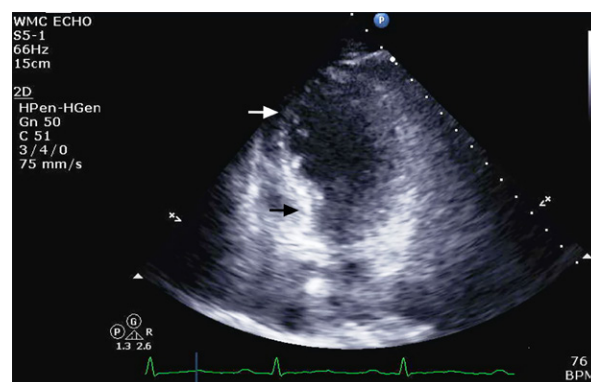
Two-dimensional bedside echocardiogram (4-chamber apical view) shows balloon-like configuration of severely hypokinetic mid-distal left ventricular wall (white arrow) with preserved contractility of the basal portion (black arrow) at end-systole.
